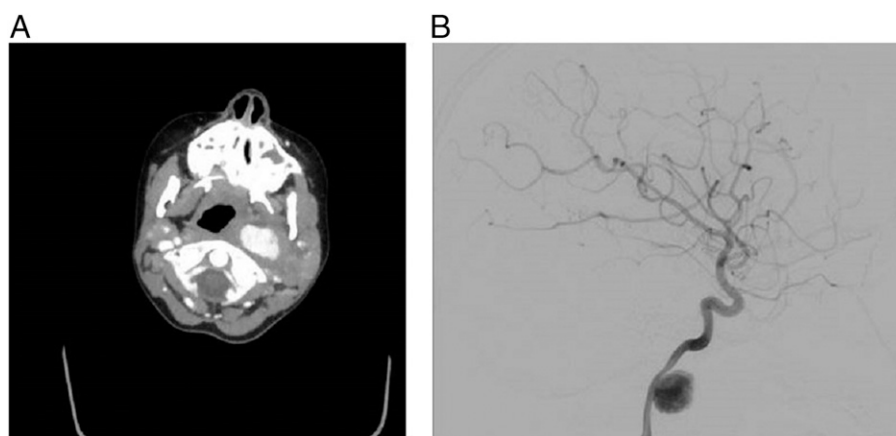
A. Contrast-enhanced computed tomographic scan showing a lobulated enhancing mass concerning for pseudoaneurysm at the level of the skull base. B. Angiogram showing left internal carotid artery pseudoaneurysm with moderate stenosis of the internal carotid artery.
